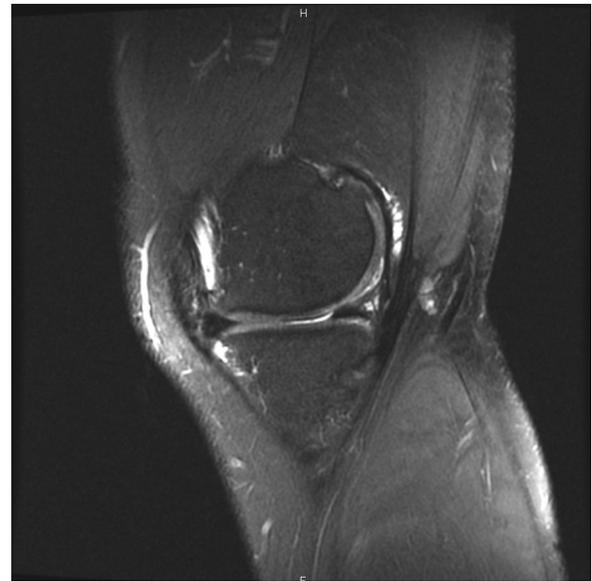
MRI, coronal view showing no evidence of meniscal extrusion after 2 years (patient #5).
